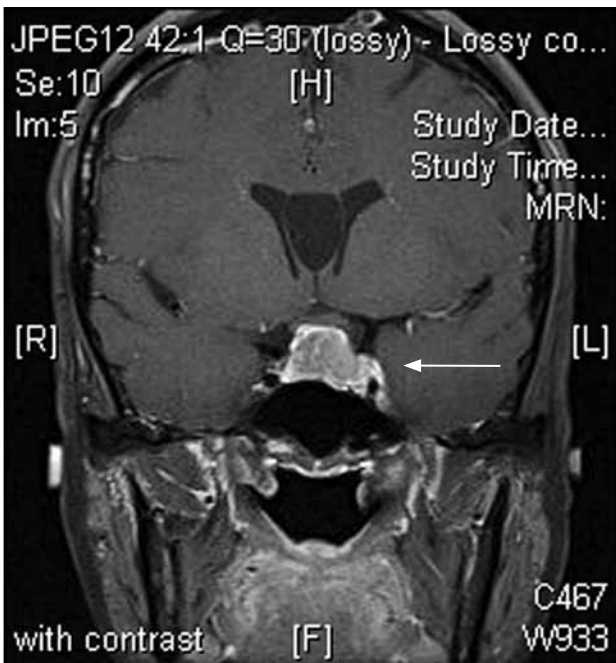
Contrast-enhancing lesion with invasion to the left cavernous sinus (arrow) on magnetic resonance imaging.
